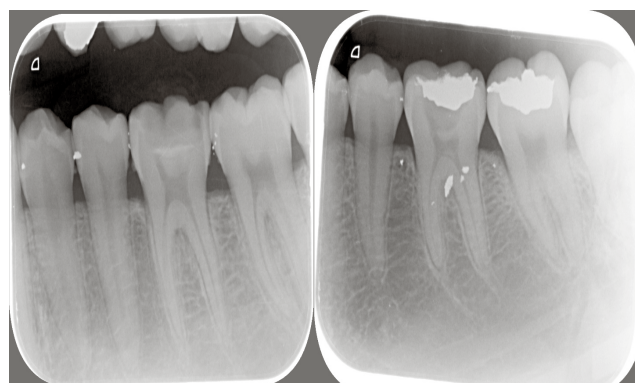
Radiographic images before and after treatment with the propolis agent
